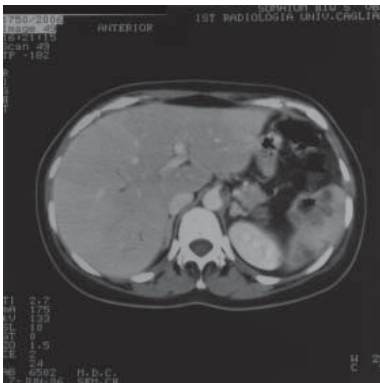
Wall thickening of the left flexure of the colon indistinguishable from the spleen parenchyma (Axial CT-scan).
